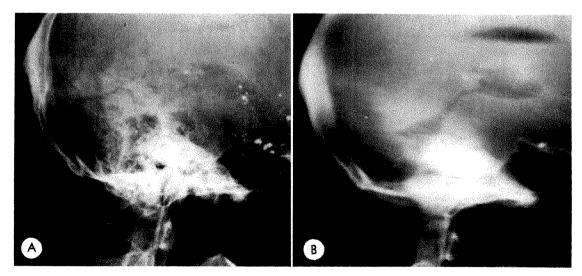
(A) Roentgenogram taken after the injection of 8 cc. of gas. The fourth ventricle is obscured by the mastoid air cells. (Droplets of pantopaque remain in the basal cisterns from a previous myelogram.) (B) Autotomographic visualization of the fourth ventricle, aqueduct of Sylvius and posterior part of the third ventricle after the injection of an additional 4 cc. of gas. Note the increase in definition of the midline structures, both within the brain and at the base of the skull.
